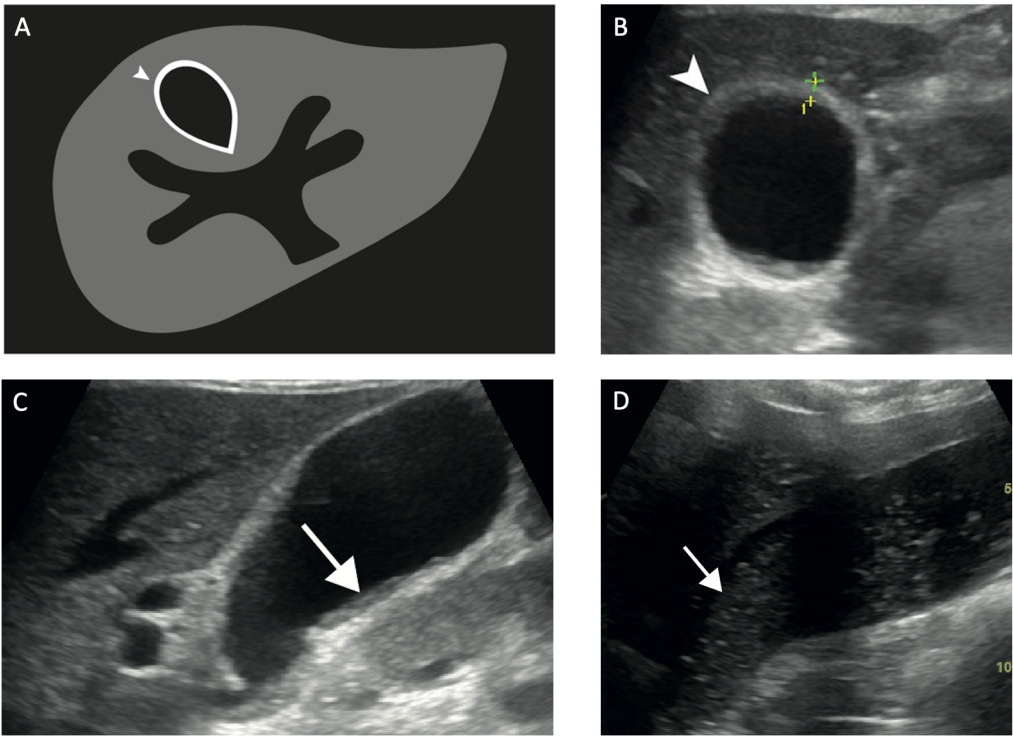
Signs of biliary abnormalities in individuals admitted to the ICU for severe COVID19: (A) Representation of gallbladder parietal thickening on ultrasound. In (B), (C), and (D), the gallbladder exhibits thickened walls (indicated by arrowheads) and dense bile content (indicated by white arrows).
